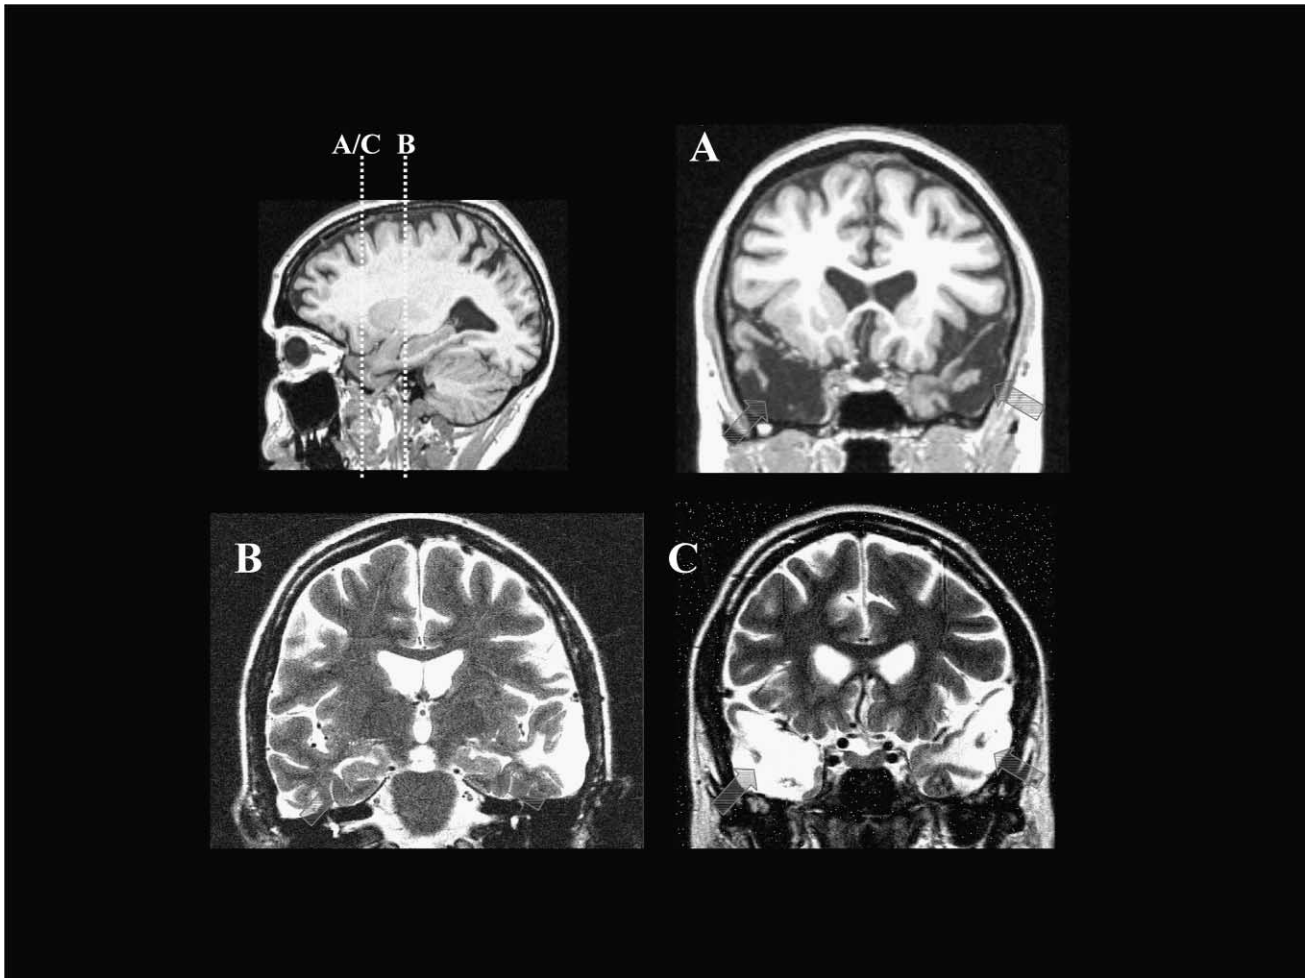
MR images for patient JL. Sagittal T1-weighted image (top-left) showing the location of images A/C. (A) Coronal T1-weighted image showing extensive damage to the anterior temporal lobes bilaterally (arrows); (B) heavily T2-weighted image obtained with fluid attenuated inversion recovery (FLAIR) sequence that shows the hippocampus appears to be normal bilaterally (arrows); (C) a FLAIR image, corresponding to (A), which shows the abnormal appearance on a heavily T2-weighted image of the anterior temporal lobes bilaterally. The images follow radiological convention, i.e. the left side of the image corresponds to the right side of the individual's brain.
